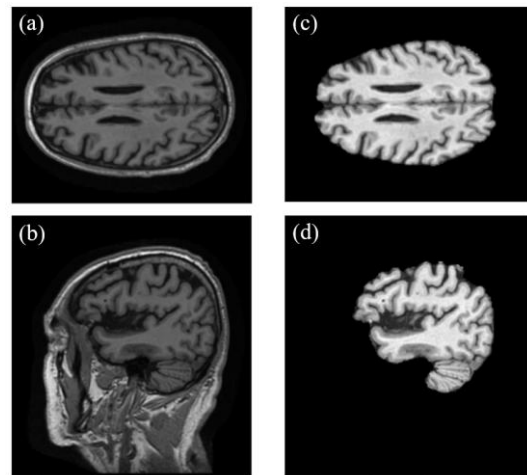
A sample of ADNI dataset images before and after skull removal in axial and sagittal views. MRI slices in (a) axial view and (b) sagittal view. The same MRI slices are shown after skull removal in (c) the axial view and (d) the sagittal view.
